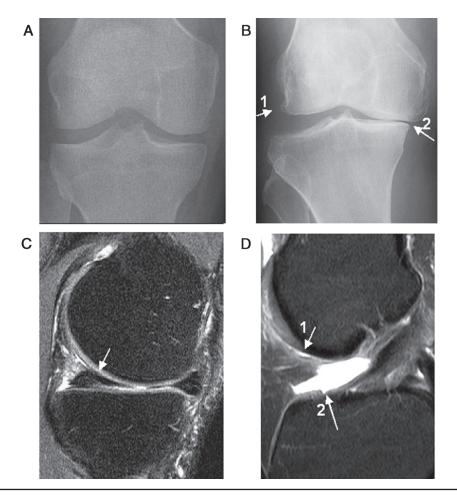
Radiographic and magnetic resonance imaging of normal and osteoarthritis (OA) knee joints. (A) Radiograph of a normal healthy knee and (B) radiograph of a knee with advanced OA with typical joint space narrowing. Arrows point to (1) osteophyte formation and (2) joint space narrowing (C). Magnetic resonance imaging of a normal knee. Arrow pointing to healthy cartilage around the rim and (D) OA knee. Arrow pointing to (1) thinning of cartilage and (2) excess synovial fluid in the joint space.
